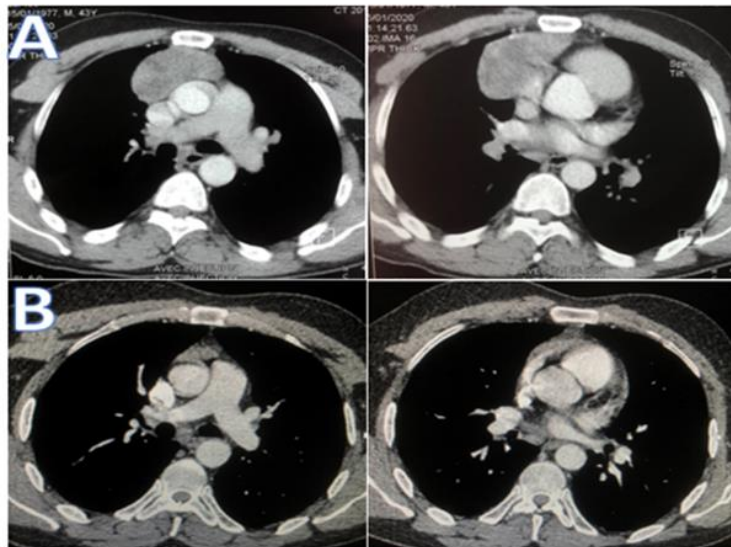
A-Chest computed tomography (CT) on the first admission shows a large mass 42*97*64mm
